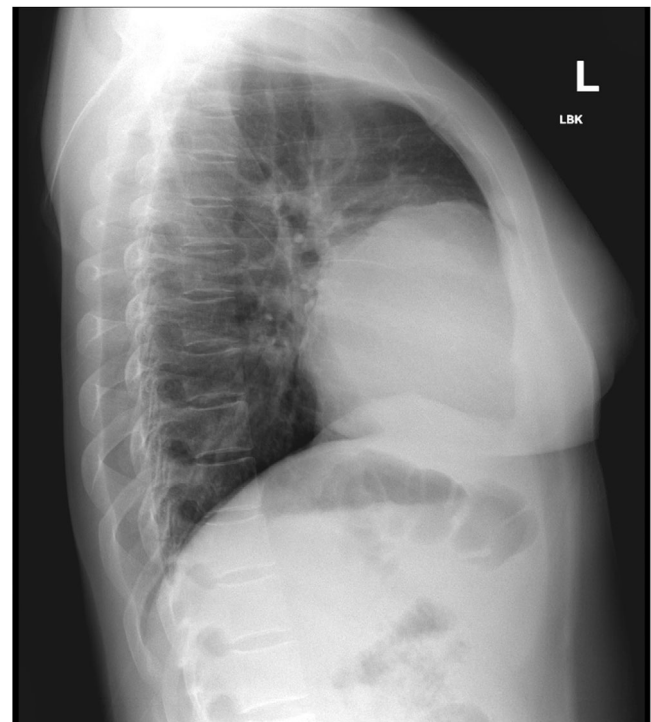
Lateral chest X-ray
